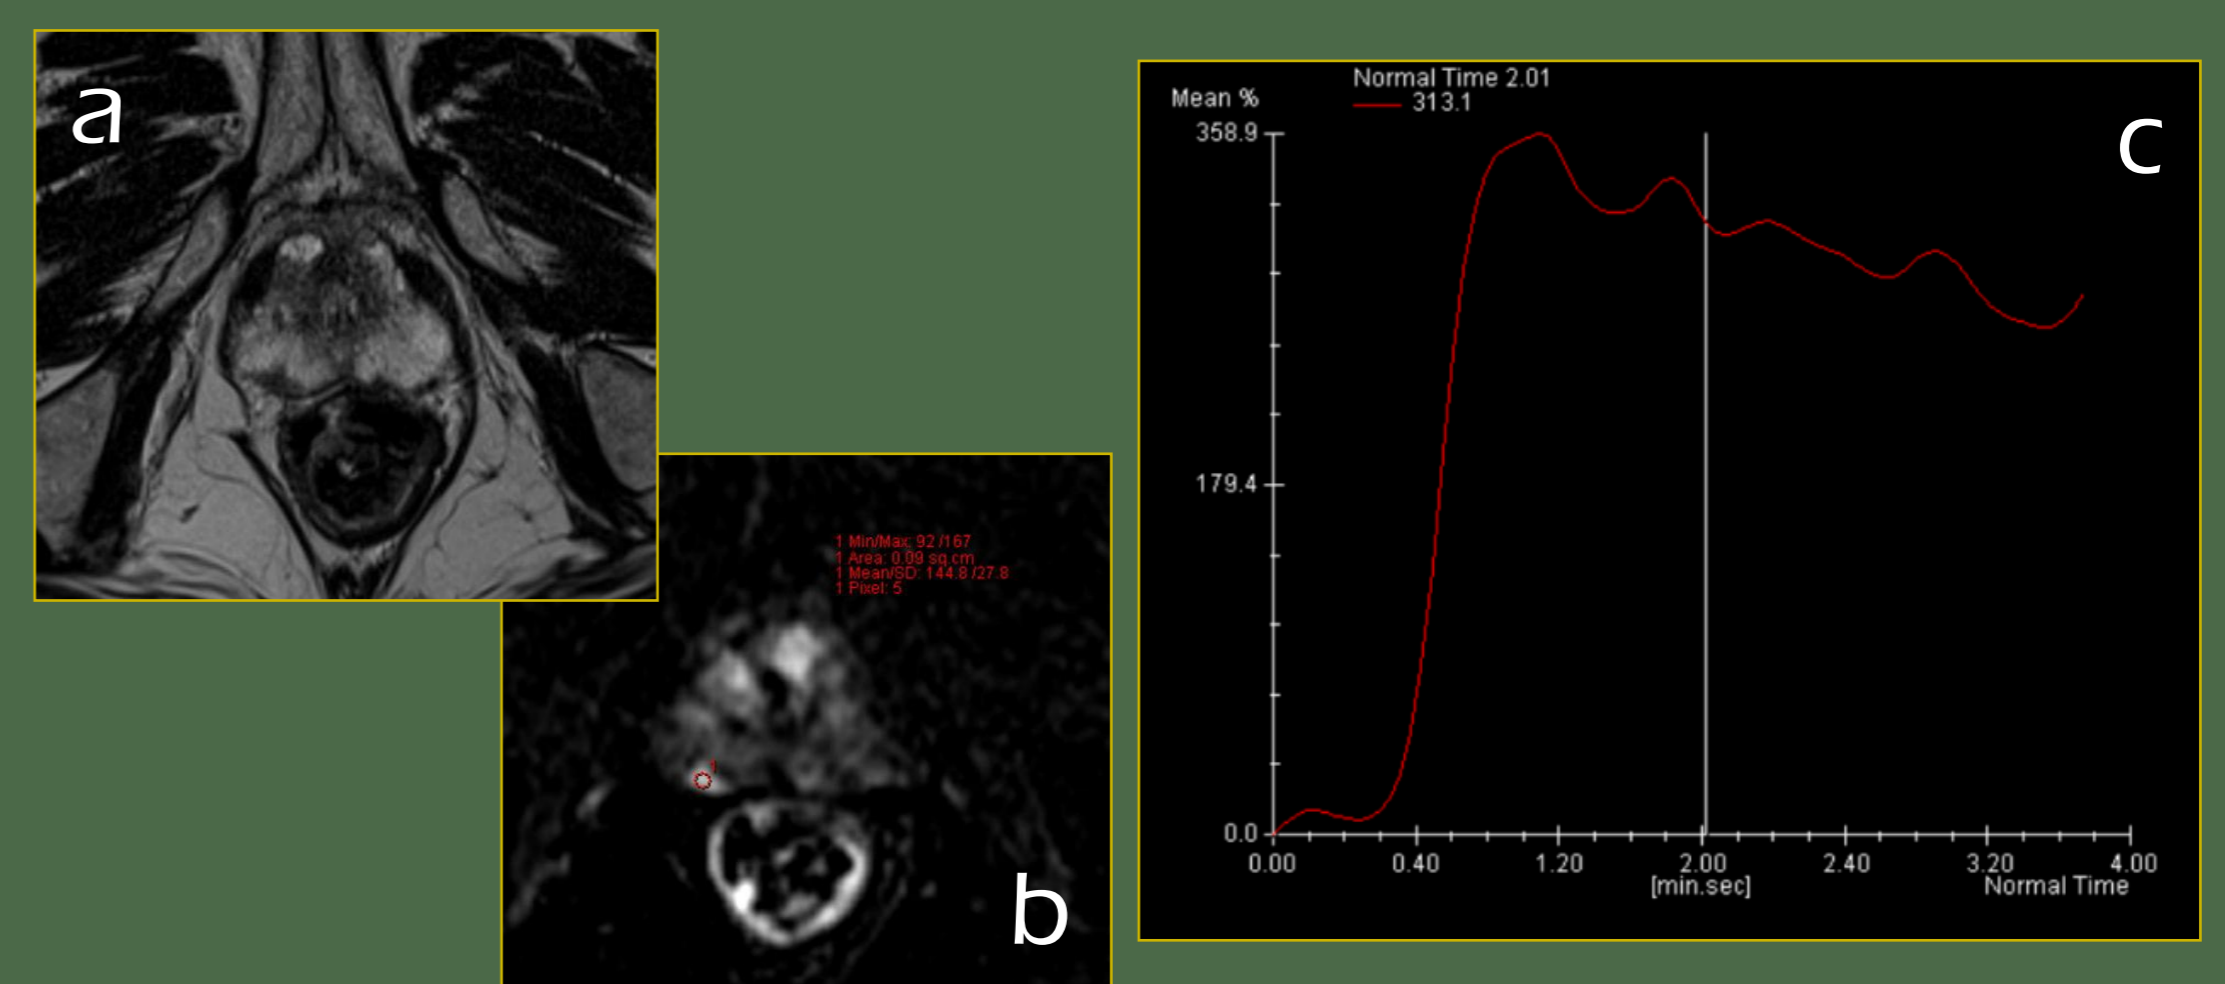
Images in a 76-year-old man with persistent high PSA level of 11 ng/mL and an initial negative biopsy. Axial T2-WI (a) show a 11 mm hypointense nodule within the right peripheral zone. The suspicious area demonstrates early enhancement on post-gadolinium T1-WI (b) and the obtained time–signal intensity curve (x-axis, time in seconds; y-axis, signal intensity in mean percentage) (c) shows a moderate washout following the fast and high peak enhancement. The second biopsy was ultrasound-guided to the suspicious nodule and revealed an adenocarcinoma in with Gleason score of 6.
